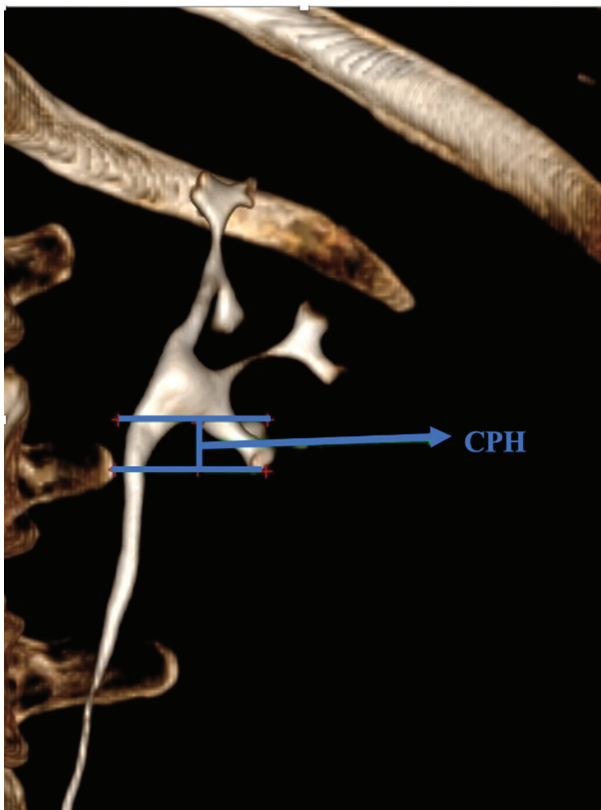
3D Volume Rendered CT urography Image showing measurement of Caliceopelvic height (CPH).
